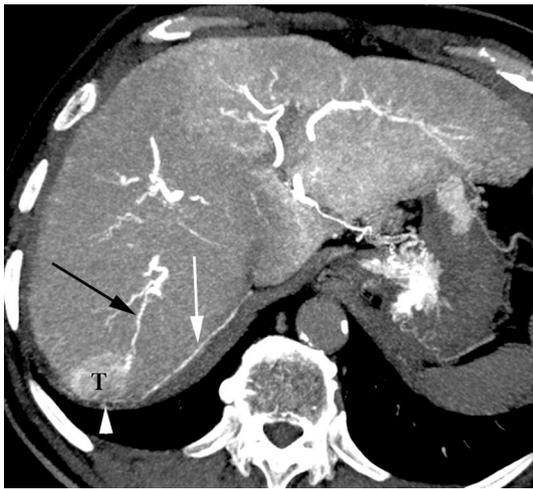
Communication between the right inferior phrenic artery and the hepatic artery through the tumor and capsular arteries demonstrated on the CT during hepatic angiography. The right posterior hepatic artery (black arrow) supplied the tumor (T), which abutted the posterior aspect of the liver. The contrast media filled in the tumor exuded into the capsular arteries (arrowhead) and then regurgitated into the right inferior phrenic artery (white arrow)
